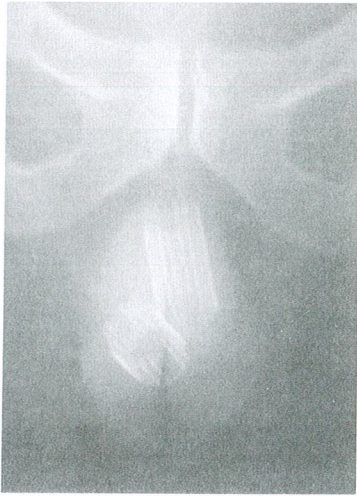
Two urethral stents in the pelvic radiograph.
